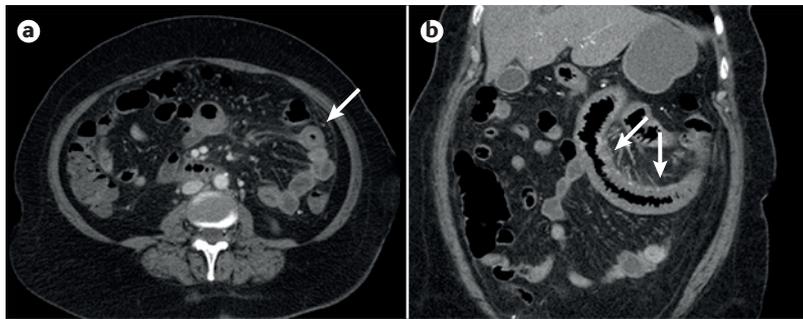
Jejunitis in a female patient with IgA vasculitis. Horizontal (part a) and coronal (part b) CT view of the abdomen demonstrates mural thickening of a long segment of the proximal jejunum (white arrows) with mild mesenteric fat stranding and mesenteric vascular engorgement.
